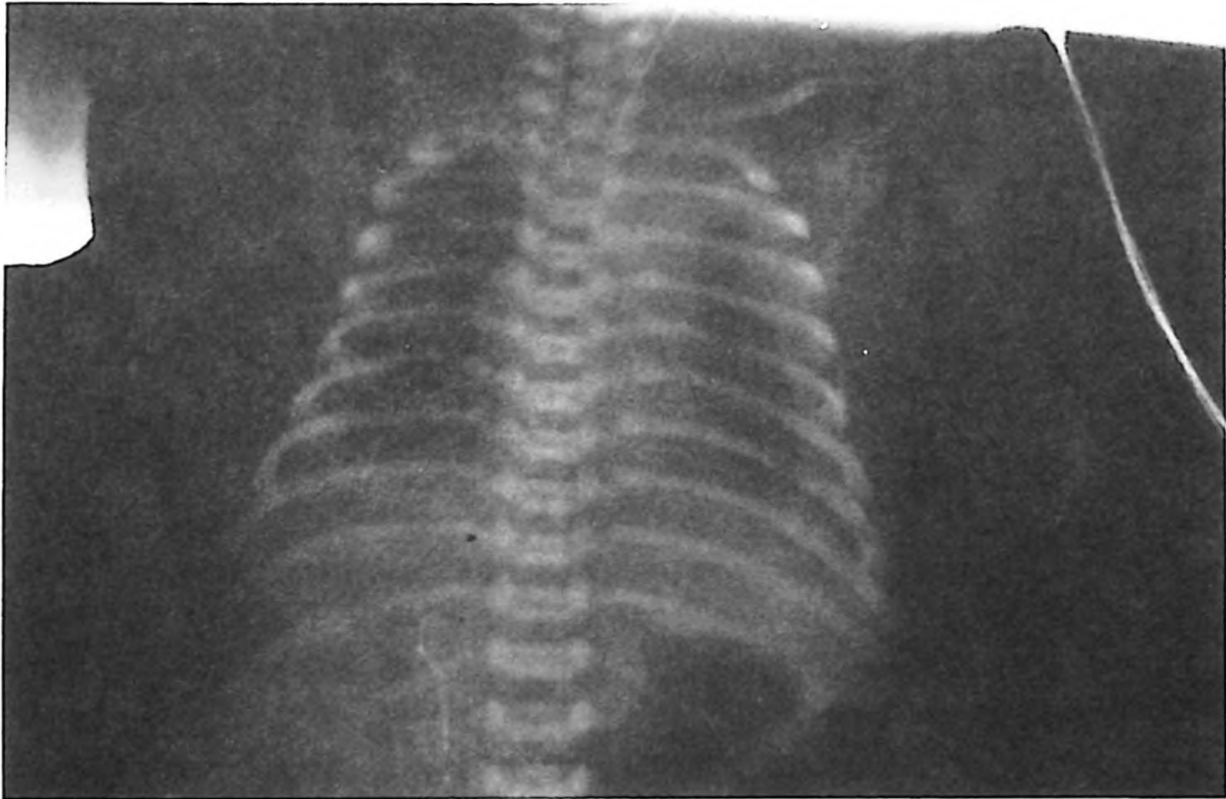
Chest x-ray two hours after birth. Bilateral pleural fluid, especially in left hemithorax, and relatively good aeration of the right lung.
